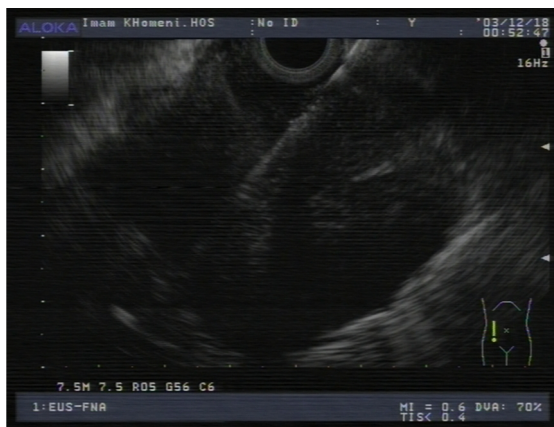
Fine needle aspiration of the mass during endosonography.
